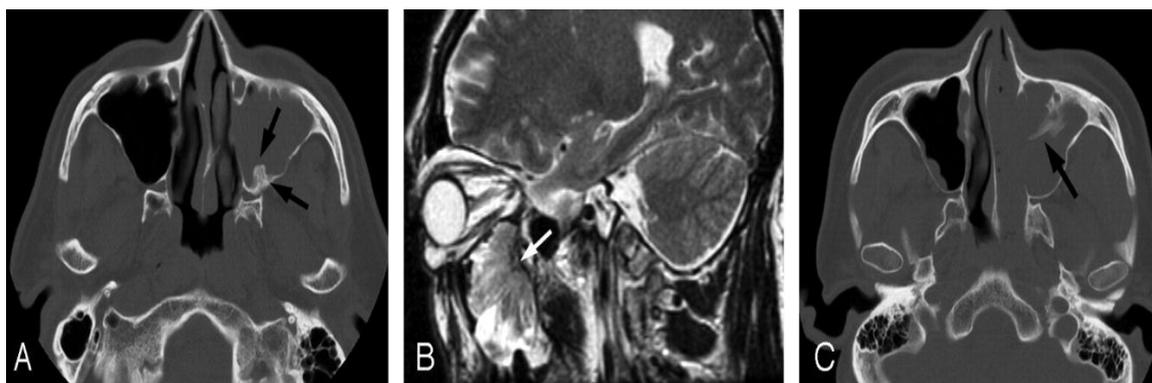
Inverted papilloma Axial CT scan and MRI.^[17]
